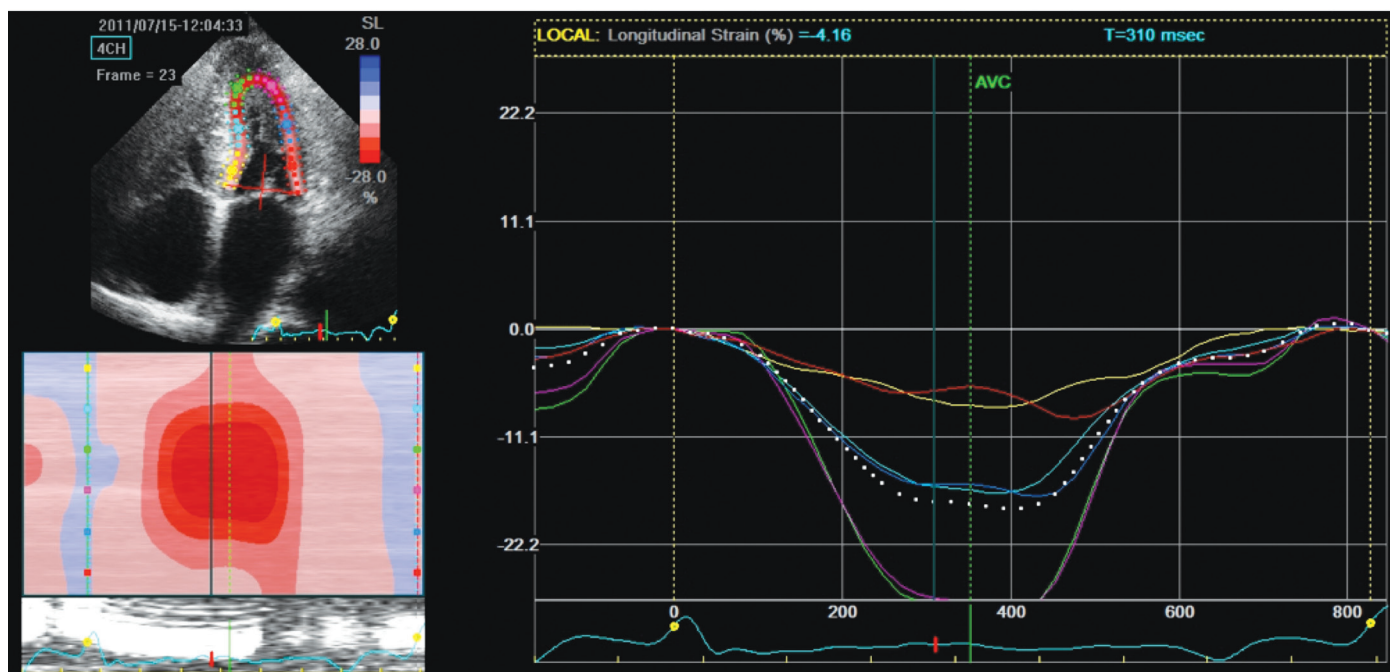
FIGURE e65-3 Echocardiogram of familial amyloid cardiomyopathy. The “bull’s-eye” appearance of the longitudinal strain pattern from an echocardiographic apical four-chamber view is shown in a patient with familial amyloid cardiomyopathy and a normal ejection fraction. The appearance represents a gradient of longitudinal strain from the apex to the base with relatively well-preserved apical strain and severely impaired basal strain. In contrast, normal subjects have no significant strain gradient from the apex to the base. This appearance, a useful diagnostic finding, is seen in more than 80% of patients with cardiac amyloidosis.
